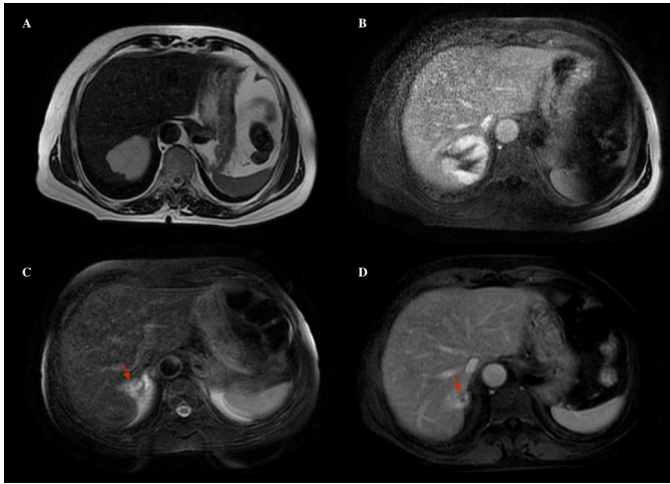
MRI follow-up of the same patient shown in Figure 1, demonstrating treatment response after TAE with a bleomycin–lipiodol emulsion. (A, B) Pre-procedural MRI reveals a lobulated, hyperintense hemangioma in the right hepatic lobe on axial T2-weighted imaging (A) and typical peripheral nodular enhancement on post-contrast T1-weighted imaging (B). (C, D) Corresponding 12-month follow-up images show marked volumetric regression, with near-complete resolution of the lesion on both T2-weighted (C) and post-contrast T1-weighted (D) sequences, consistent with a favorable therapeutic response.
